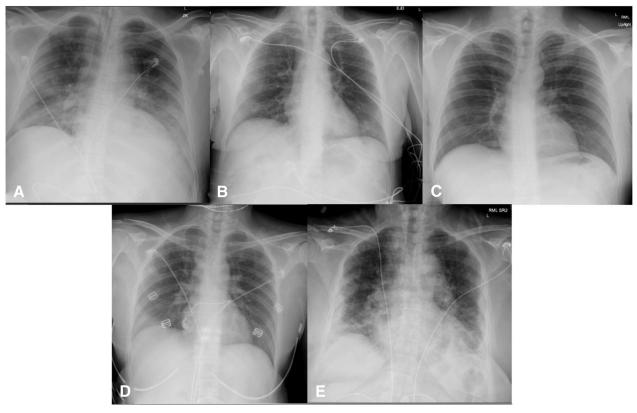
Features of chest radiograph of selected cases. (A) Case 1, bilateral interstitial opacifications with endotracheal tube in place. (B) Case 2, mild interstitial prominence of left lower lobe. (C) Case 3, clear chest. (D) Case 4, developing right upper and lower interstitial prominences. (E) Case 5, extensive severe bilateral disease with interstitial and basilar predominance.
